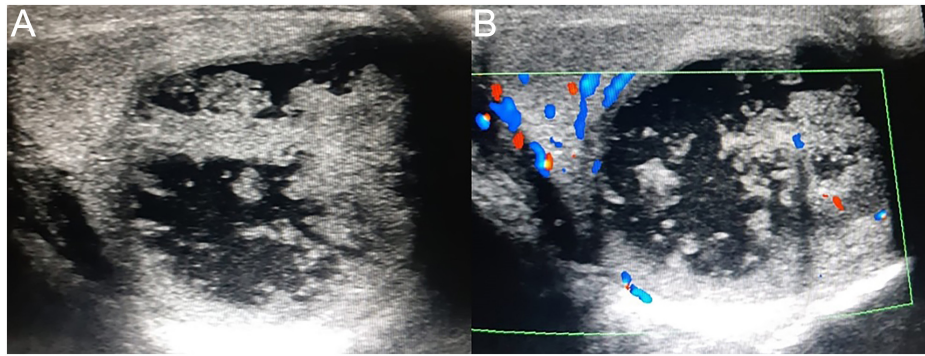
(A, B) Thick-walled cystic-necrotic abscess formations observed in the right testis, resulting in loss of the intact testicular parenchyma during ultrasound examination (A). No vascular signal was coded in necrotic abscess formations in the Doppler ultrasound examination. Instead, note the increased blood flow in the epididymis and testicular parenchyma (B).
